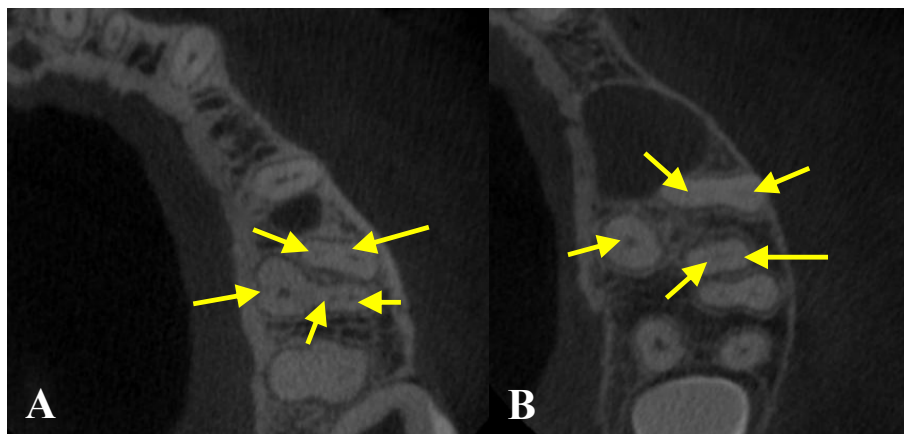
(A and B) CBCT images of two maxillary first molar teeth with five canals appreciated from the axial view. The yellow arrows show all of the canals.
